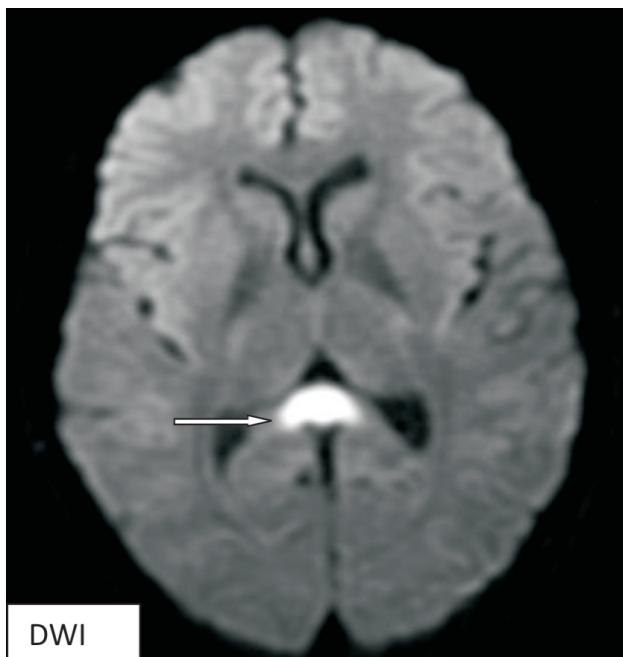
Showing ovoid hyper intense lesion in central part of SCC on DWI and T2WI.
